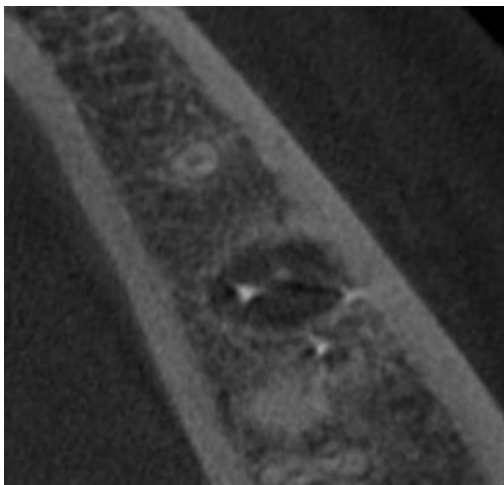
CBCT Axial View of #19
